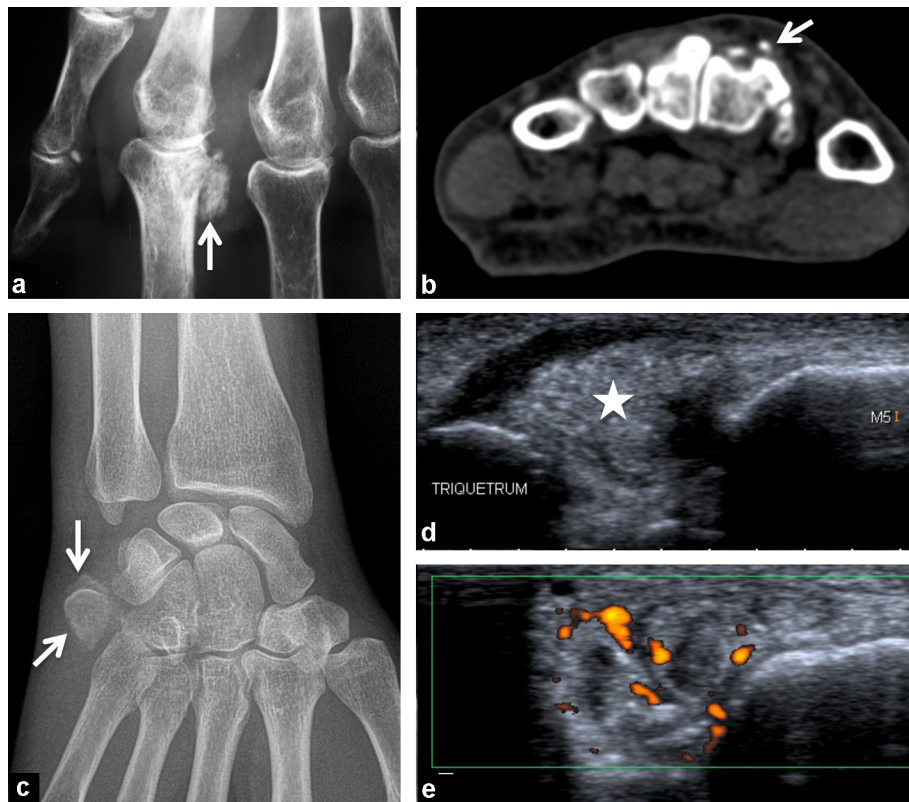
Acute deposits of hydroxyapatite crystals in the soft tissues of three different patients: on conventional radiography at the base of P1 of the 2nd ray (arrow) (A), on axial CT scan at the distal insertion of the extensor carpi radialis longus muscle on the 2nd metacarpal base (arrow) (B), on conventional radiography (arrows) (C), ultrasound (D) and Doppler ultrasound near the triquetral bone and the distal insertion of the extensor carpi ulnaris (E). Note on ultrasound the echogenic mass with the calcium spots and no posterior shadow cone (D-star) and the Doppler hyperhemia consistent with the local inflammation (E).
